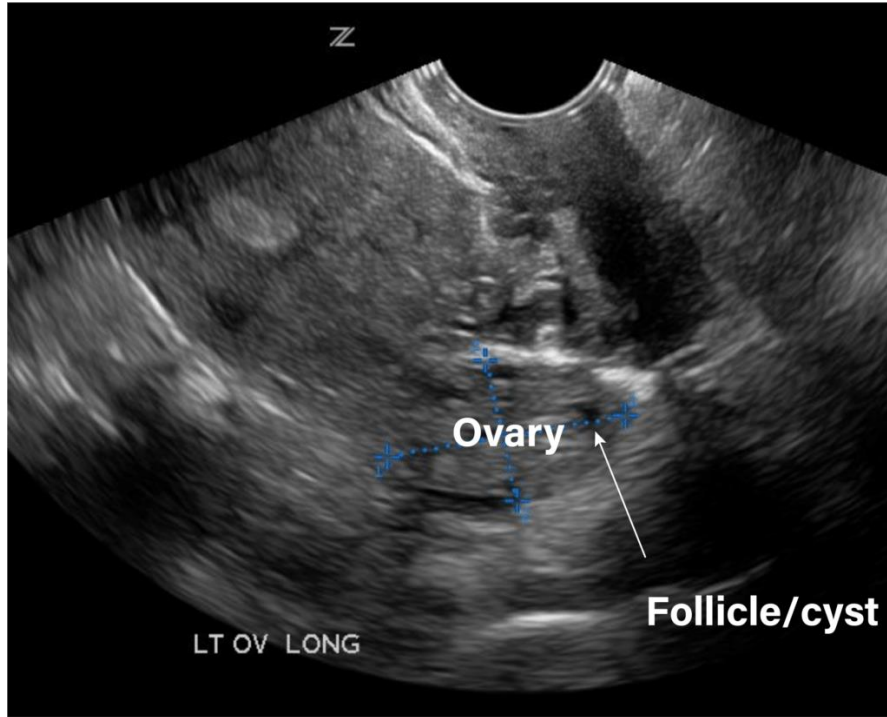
Normal ovary with follicle/cyst; transvaginal ultrasound adopted form Ujaddughe O et al., 2024
